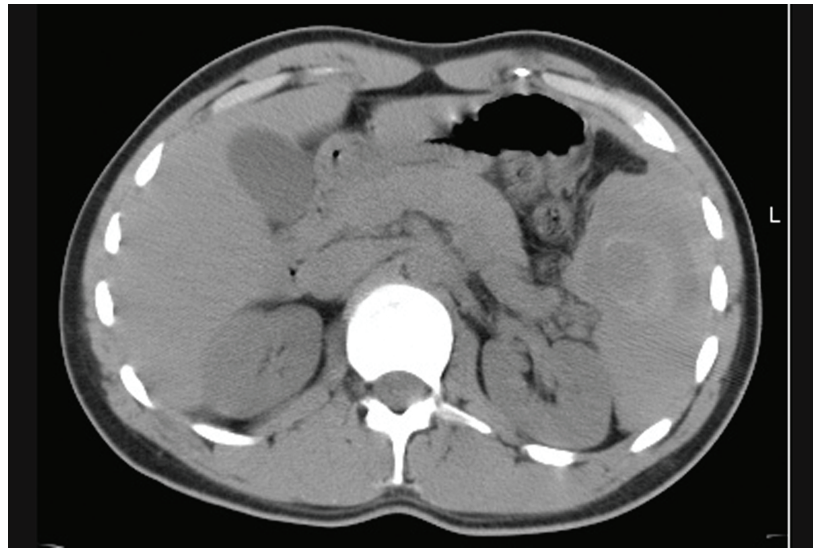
CT Ruptured Spleen and Hemoperitoneum
